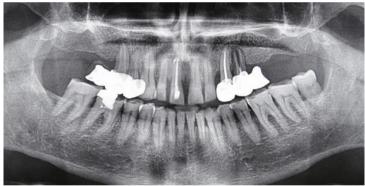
Panoramic radiographic evaluation of the patient (initial)
